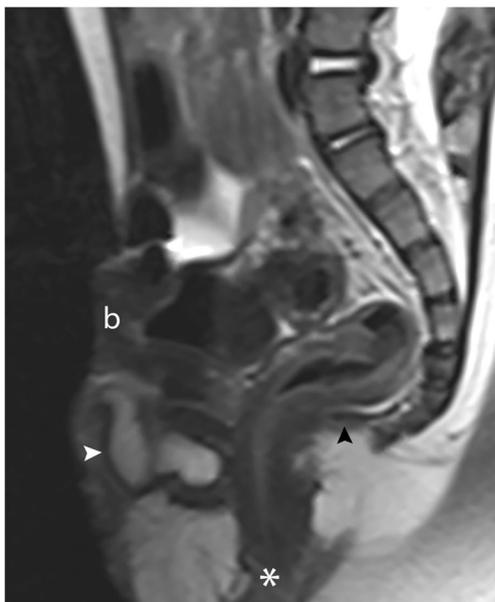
MRI assessment of the CBE male. Sagittal T2-weighted MRI at the level of the pelvic midline. The bladder template (b) is exposed. Pelvic floor musculature (black arrowhead), which is depicted as a thin layer of soft tissue with low T2 signal intensity, is flattened. There is anterior displacement of the rectum and anus (asterisk). Paired corpora cavernosa are identified by their high T2 signal. The phallus in males is shortened due to diastasis of the pubic symphysis, congenital deficiency of the anterior corpora, and dorsal chordee (white arrowhead)
